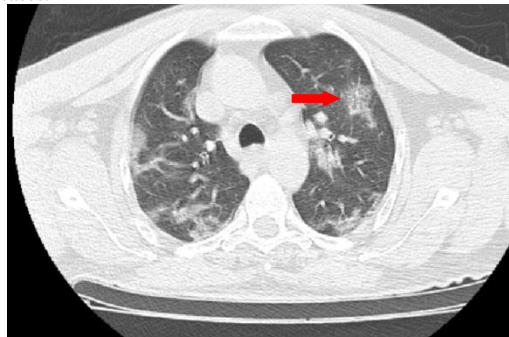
Axial HRCT CHEST lung window of patient after 3 days from onset of symptoms (Stage 1) shows ground glass opacities in the central and peripheral aspects of the left lung.
